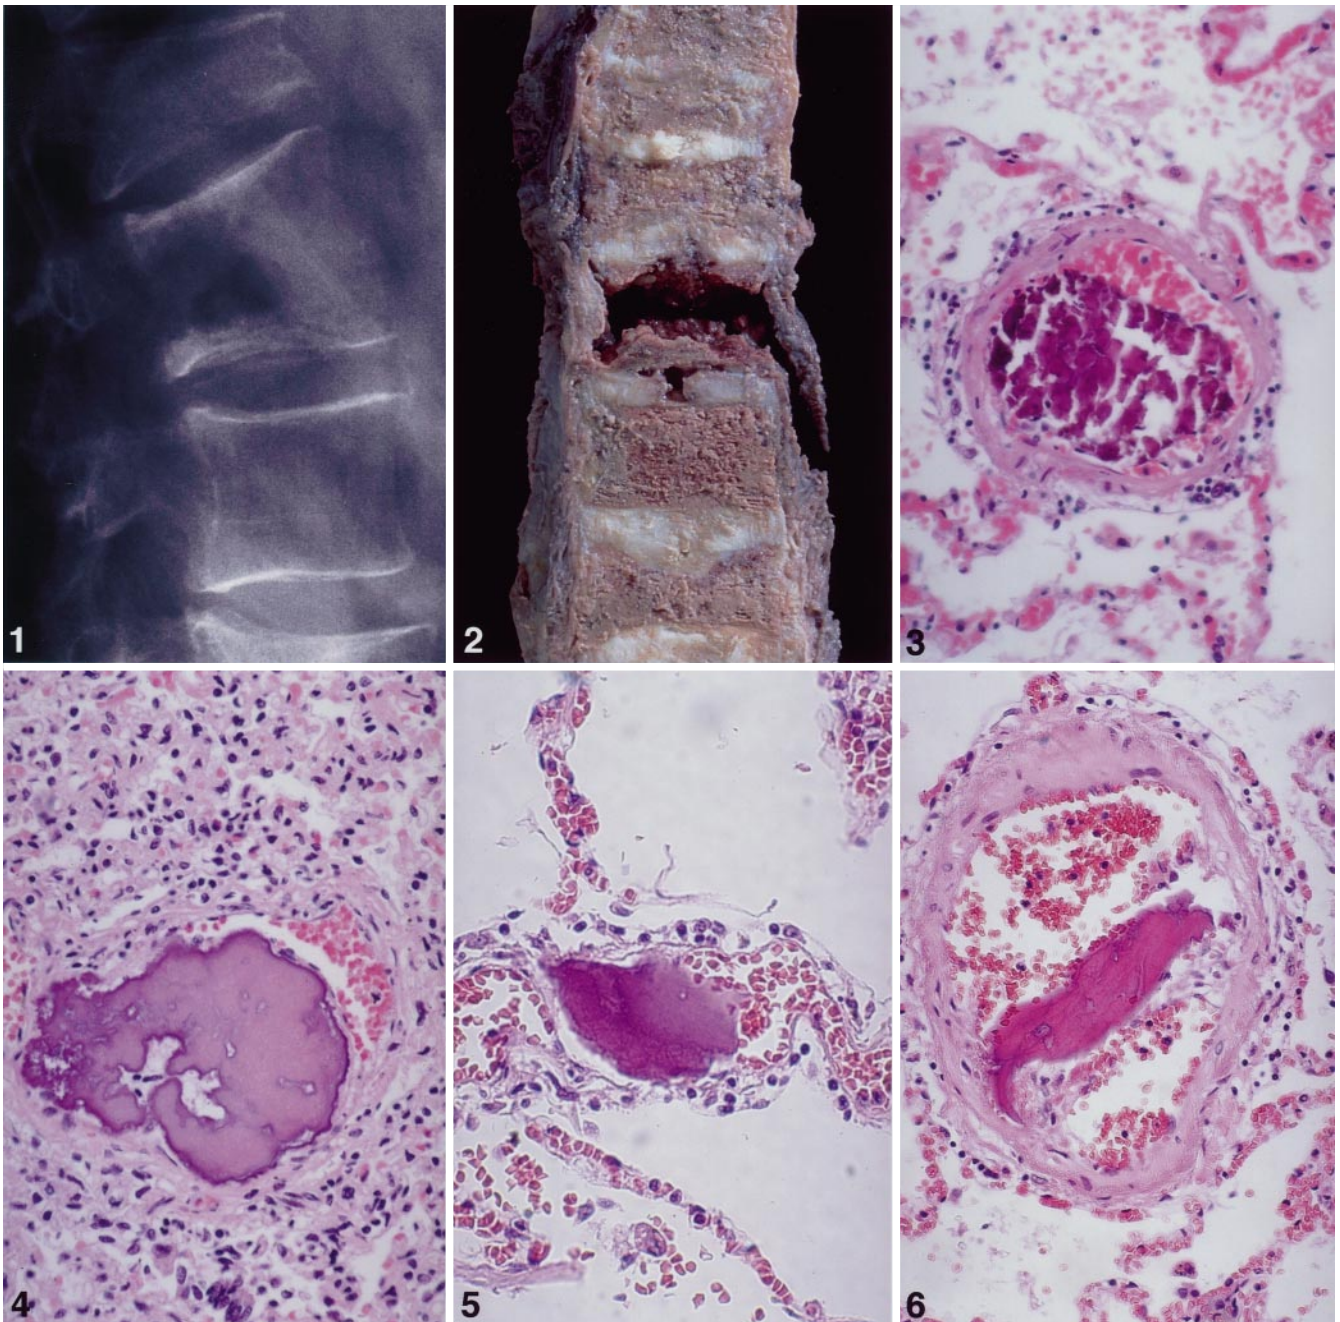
X-ray of lumbar spine in case 1: lateral view of L1 shows osteolytic lesion with sclerosed rim and impression fracture
